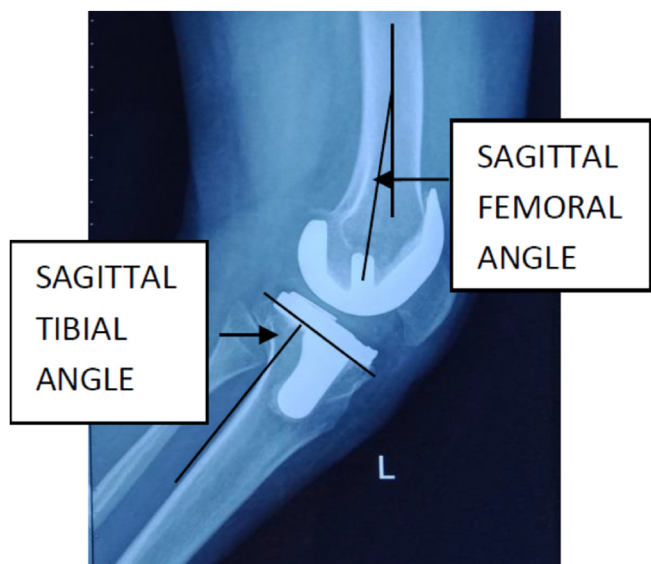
Post-operative radiograph showing Sagittal Femoral Angle and Tibial Angle.
